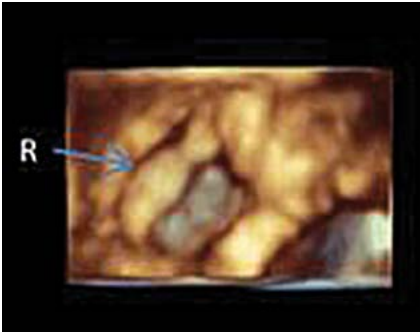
En face view through the tricuspid valve from apical 4-chamber (R – ridge)
